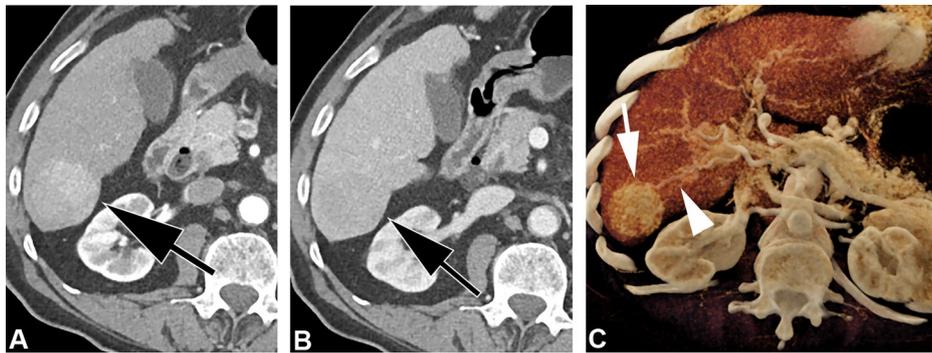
A 79-year-old man with history of hepatitis B and hepatitis C with hepatocellular carcinoma. A. Two-dimensional CT image obtained in the axial plane during the arterial phase of enhancement shows a subtle, hypervascular mass (arrow) in the lateral section of the right liver. B. Two-dimensional CT image obtained in the axial plane during the venous phase of enhancement shows characteristic washout (arrow) compatible with hepatocellular carcinoma. C. CT image obtained in the axial plane during the arterial phase of enhancement with cinematic rendering can increase the conspicuity of the liver mass (arrow) and the feeding artery (arrowhead).
